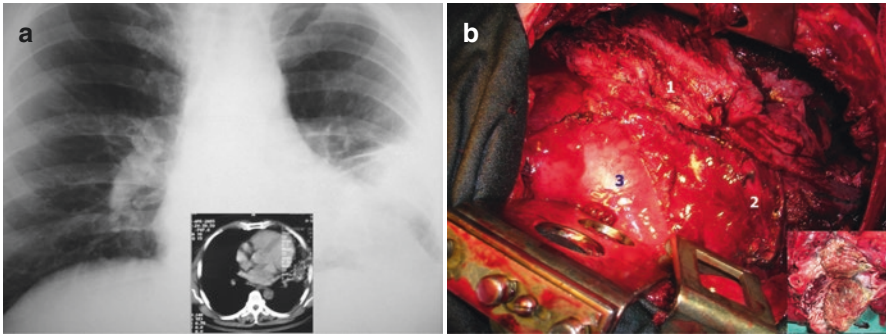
Bronchiectasis with lung abscess with a CT aspect suggestive of malignancy
